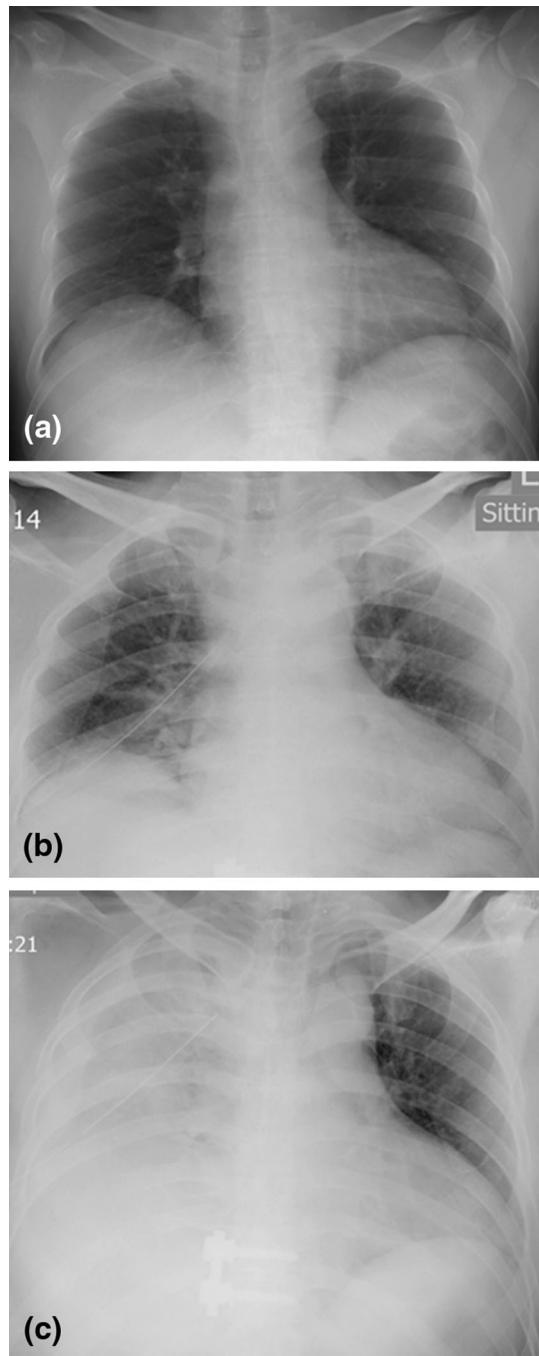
Chest x-ray taken a preoperatively was clear. Subsequent X-rays taken after the T9/10 anterior decompression and instrumented fusion at b 6 h postoperatively showed no hemothorax but a massive right hemothorax was observed at c 14 h postoperatively
